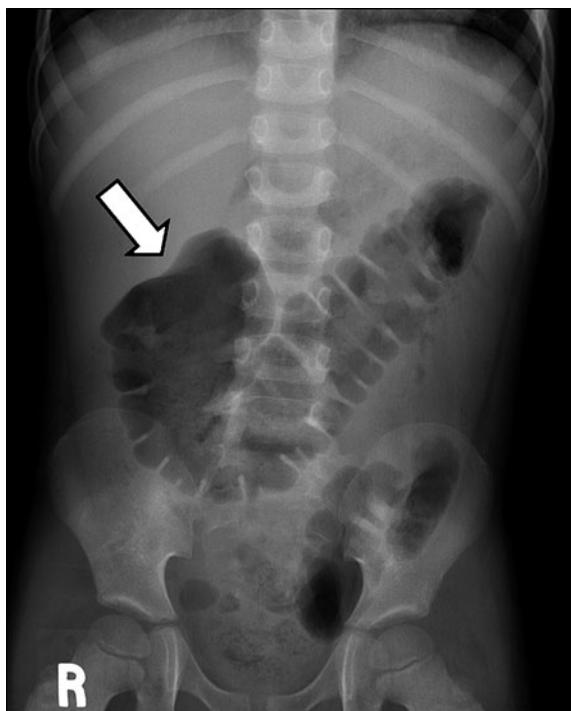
Five-year-old boy with acute appendicitis. Supine abdominal radiograph demonstrates distended transverse colon and empty ascending colon with a sharp demarcation (*arrow*) of these two segments
